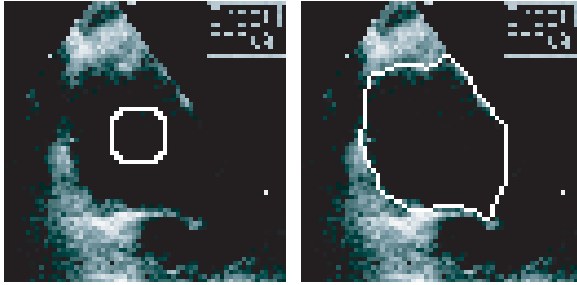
Processing on the first frame in a echocardiography image sequence. The initial contour on the left (from the previous frame) and the final contour on the right.
